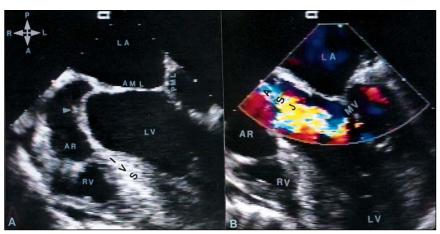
Transesophageal echocardiogram of a 50-year-old male patient with severe isolated aortic stenosis originating in a bicuspid aortic valve. The left ventricular outflow tract view (A) shows two unequal aortic valve leaflets with an eccentric, slit-like, narrow opening (small arrowhead). The same view with color flow Doppler application (B) shows a mosaic color jet originating below the valve and traversing through the narrow orifice. Abbreviations: AML = anterior mitral leaflet; AR = aortic root; ASJ = aortic stenosis jet; IVS = interventricular septum; LA = left atrium; LV = left ventricle; MV = mitral valve; PML = posterior mitral leaflet; RV = right ventricle. Compass: A = anterior; L = left; P = posterior; R = right.
